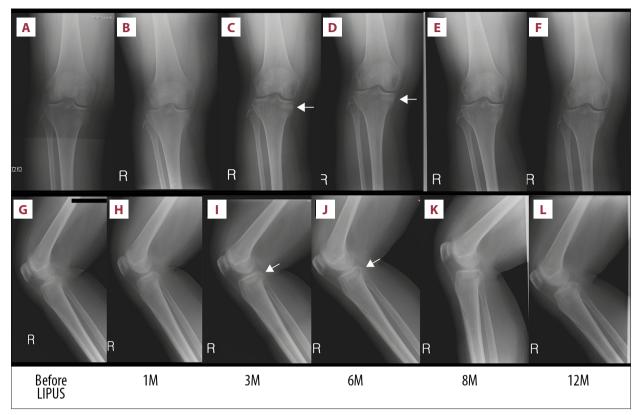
Anteroposterior (A-F) and lateral (G-L) radiographs of the right knee taken immediately after the onset of the knee pain, and 1 month, 3 months, 6 months, 8 months, and 1 year after initiation of LIPUS therapy. Obvious callus formation around the fracture site was observed at 3 and 6 months after treatment (arrows). After 1 year, remodeling of the fracture callus was complete. LIPUS, low-intensity pulsed ultrasound; M, months.
